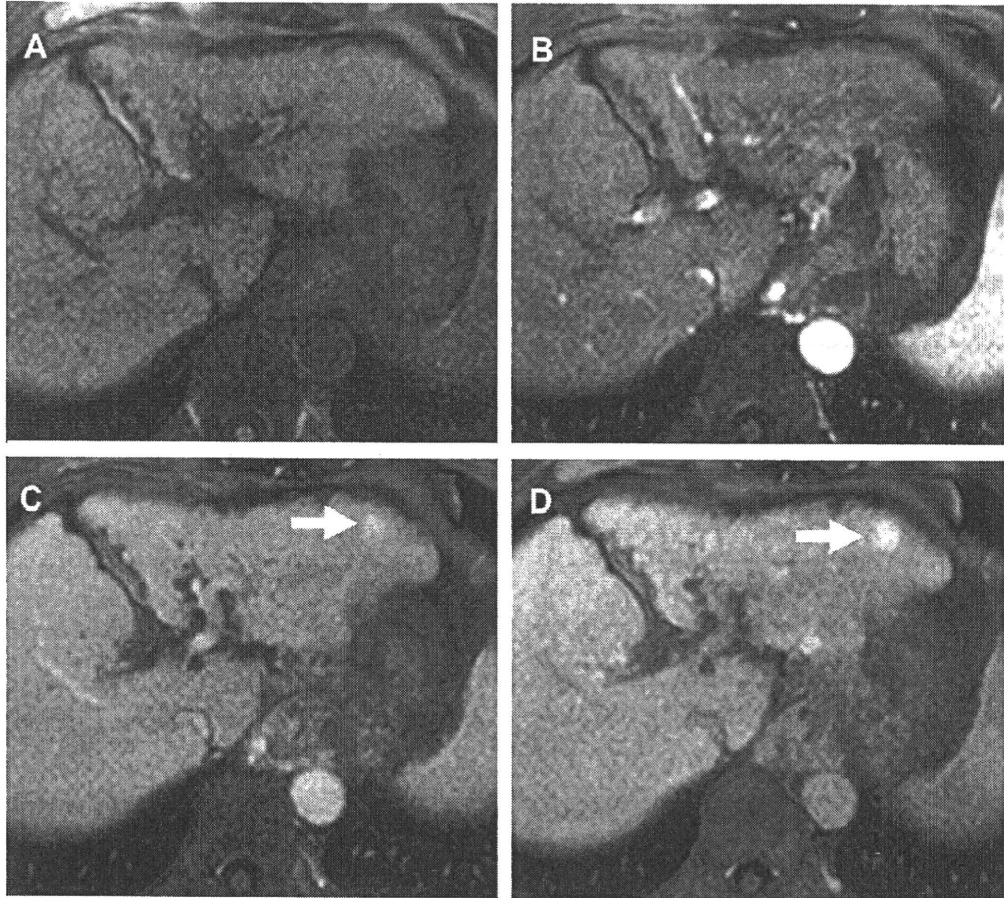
Low-grade (A, B) and high-grade dysplastic nodules (C, D). All nodules were hyperintense on T1-weighted fat-saturated 3D GRE images (TR/TE = 3.6/1.7 ms, flip angle = 15°) (A, C) (arrows). In T2-weighted fat-saturated TSE images, in contrast, a low-grade dysplastic nodule is observed as hypointense (B) (arrow), whereas a high-grade nodule is observed as slightly hyperintense (D) (arrow).
